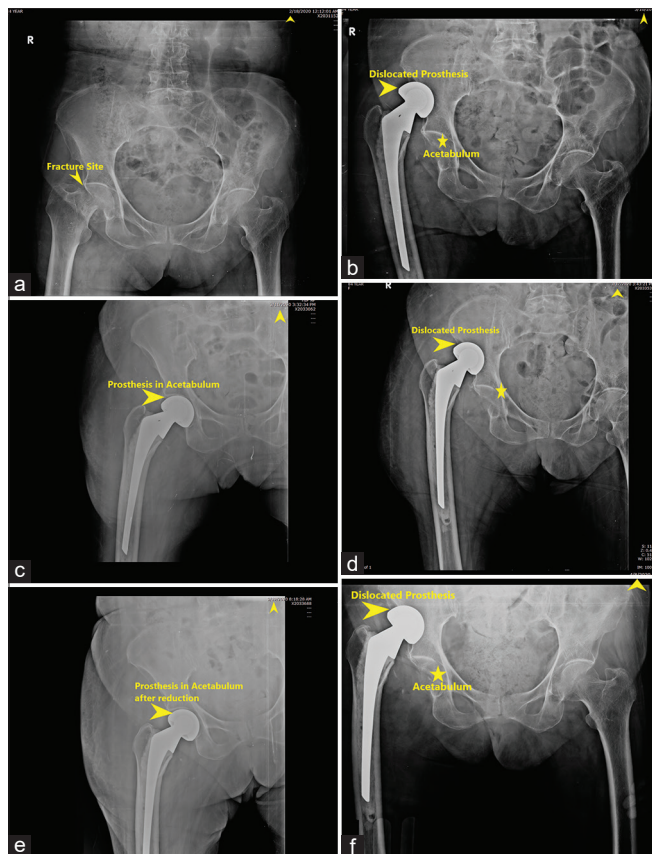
(a)-X-ray showing right side hip fracture before surgery, (b)-x-ray after 1 month of surgery showing dislocation of prosthesis on right side, (c)- check x-ray after reduction, (d)-dislocation after 1 week of reduction, (e)-check x-ray after reduction, (f)-re-dislocation after 1 month. Arrow head at right corner of each x-ray showing date of investigation
